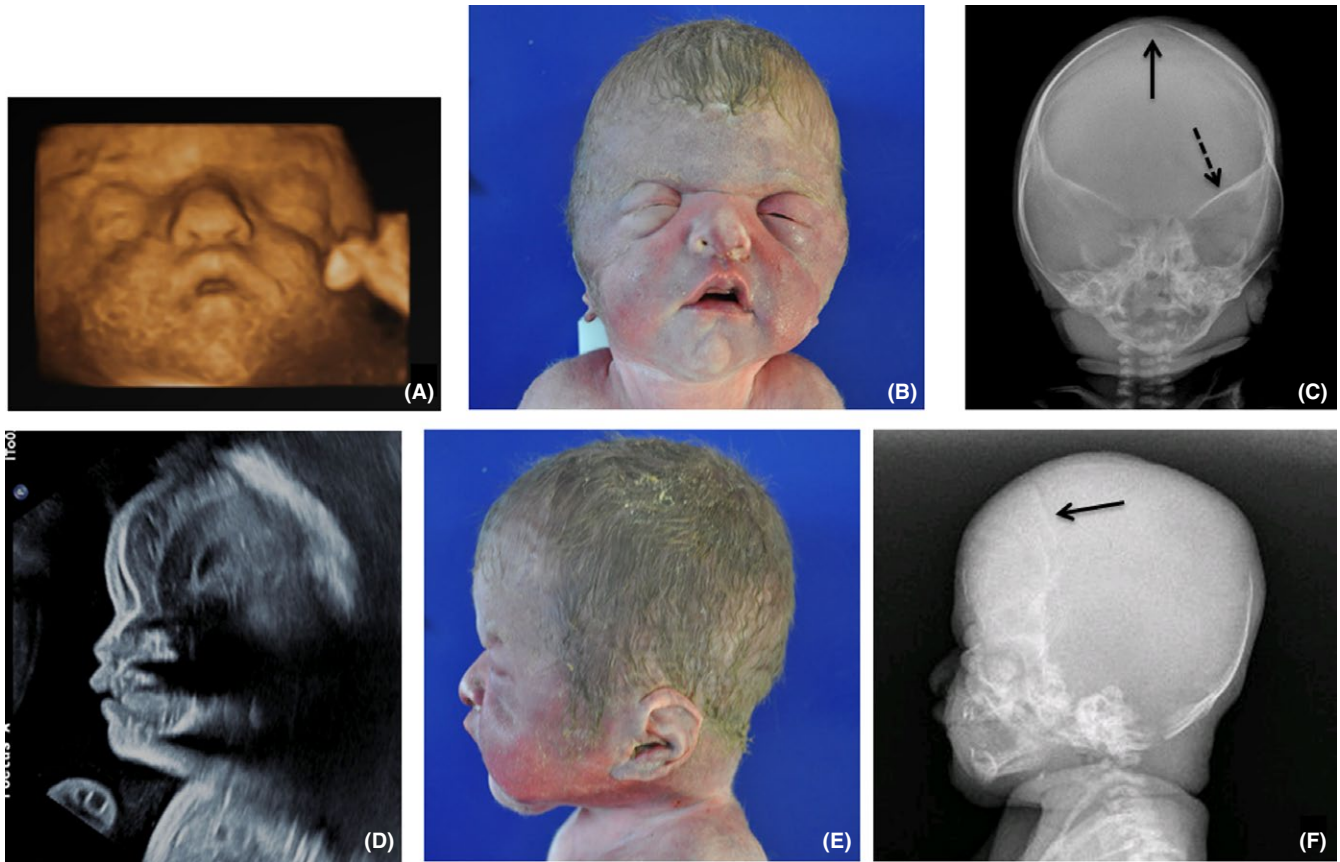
Craniosynostosis and facial dysmorphism. Prenatal 3D US (A), postmortem examination, (B) and radiography (C) of fetal face. Lateral view in prenatal 2D US (D), postmortem (E), and radiography (F). B and E. Hypertelorism, midface hypoplasia, micrognathia, down-slanting palpebral fissures. C. Frontal view showing biparietal widening, hypertelorism, upward sloping orbital margins, sphenoid wings (dotted arrow) and open sagittal suture (arrow). F. Lateral views showing brachycephalic skull, highly arched orbital roofs and characteristic appearance of the coronal sutures (arrow)
